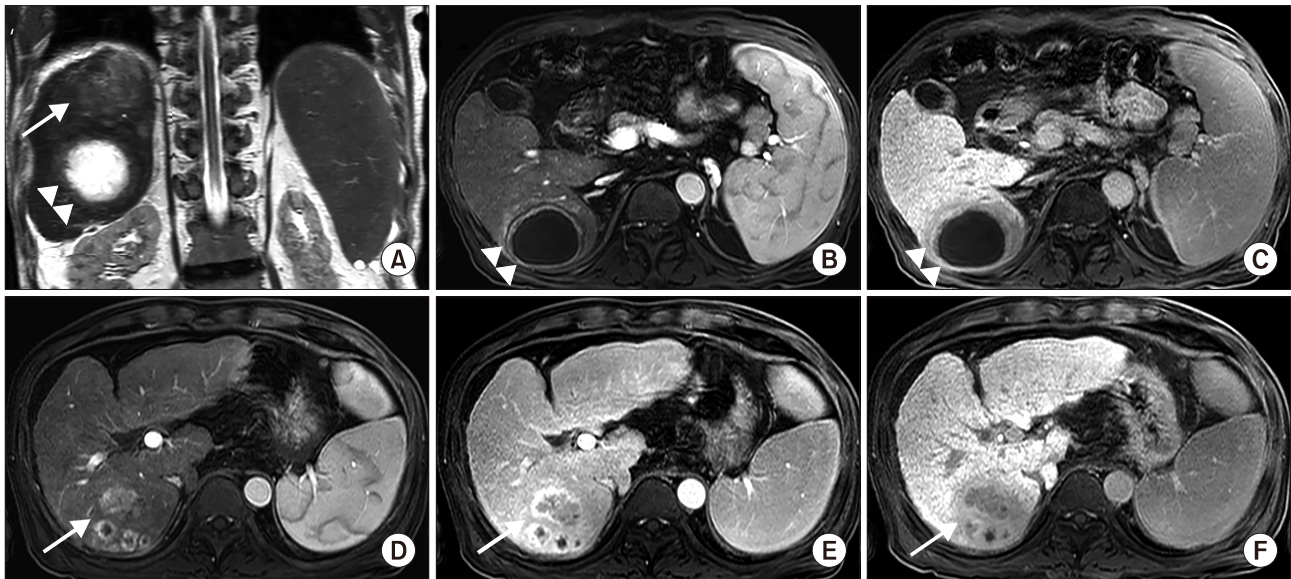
The MR images of IPTL misinterpreted as malignant hepatic tumors including intrahepatic cholangiocarcinoma (ICC), combined type HCC-ICC and tumor necrosis. (A) The coronal T2 weighted image showed more than 7 cm extent of ill-defined T2 hyperintense masses (arrow) and a 6 cm sized large cystic or necrotic mass (arrowheads) at the posterior section of the right hepatic lobe. (B) The arterial phase MR image showed peripheral enhancement and central unenhancing portion of the inferior mass (arrowheads). (C) The hepatobiliary phase MR image showed ill-defined hypointensity at the peripheral portion of the lesion (arrowheads). (D) The arterial phase MR image showed arterial enhancing mass and peripheral enhancing masses (arrow) at the superior lesions. (E) The transitional phase MR image showed persistent enhancement of the large mass and peripheral enhancement of small masses (arrow). (F) The hepatobiliary phase MR image showed ill-defined mild hypointensity of the lesions (arrow).
